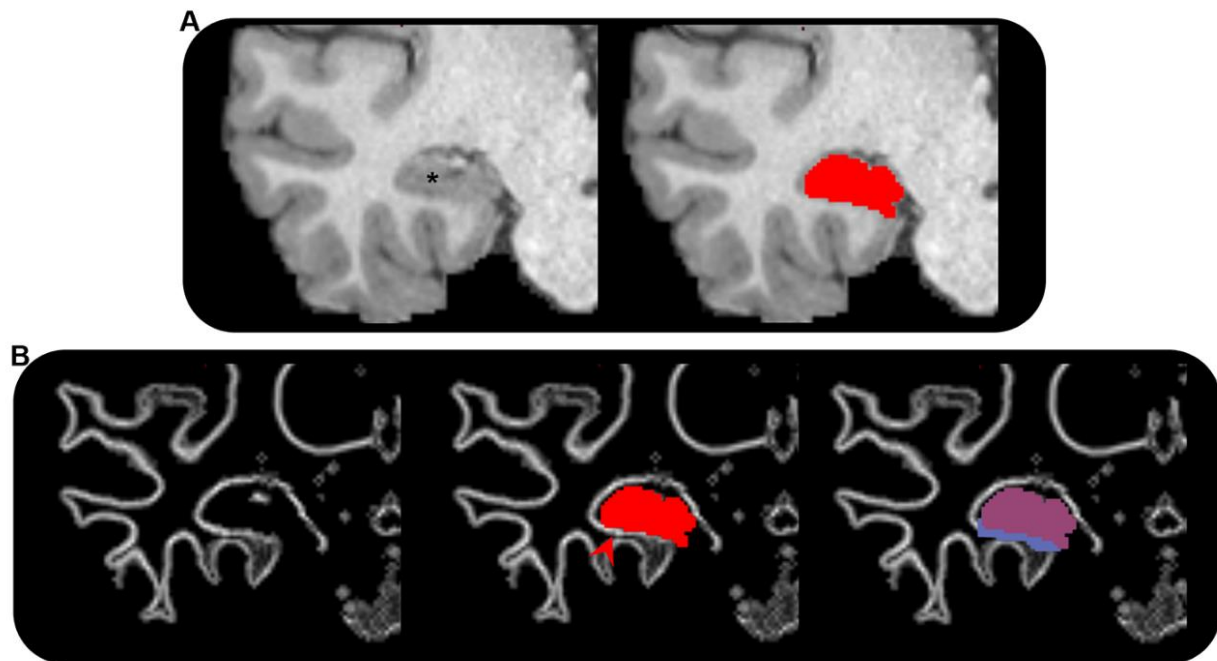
Adjustment of grey matter/white matter interface underlying the hippocampus. a. T1-weighted structural MRI scan showing the right medial temporal lobe (left; hippocampus indicated by *) in the coronal plane for a single participant and the manually segmented hippocampus mask (red) overlaid on the T1-weighted image (right). b. (left) The grey matter/white matter (gm-wm) interface (white line) showing the right medial temporal lobe in the coronal plane; (middle) the manually segmented hippocampus mask (red) overlaid on the gm-wm interface. Note: portions of detected gm-wm interface immediately inferior to the hippocampus lie outside of the hippocampus mask (indicated by red arrow). If left unchanged, the anatomically-informed tractography algorithm used in our study would terminate tracks as they reach this band, thus creating an erroneous band of track end-points in this region, introducing misleading results. (Right) The hippocampus mask (transparent red) and extended hippocampus mask (blue) overlaid on the gm-wm interface. Note: the extended hippocampus mask encompasses the gm-wm interface immediately inferior to the hippocampus. This allows streamlines to enter/leave the hippocampus here rather than terminate at the gm-wm interface (see Methods for detail).
